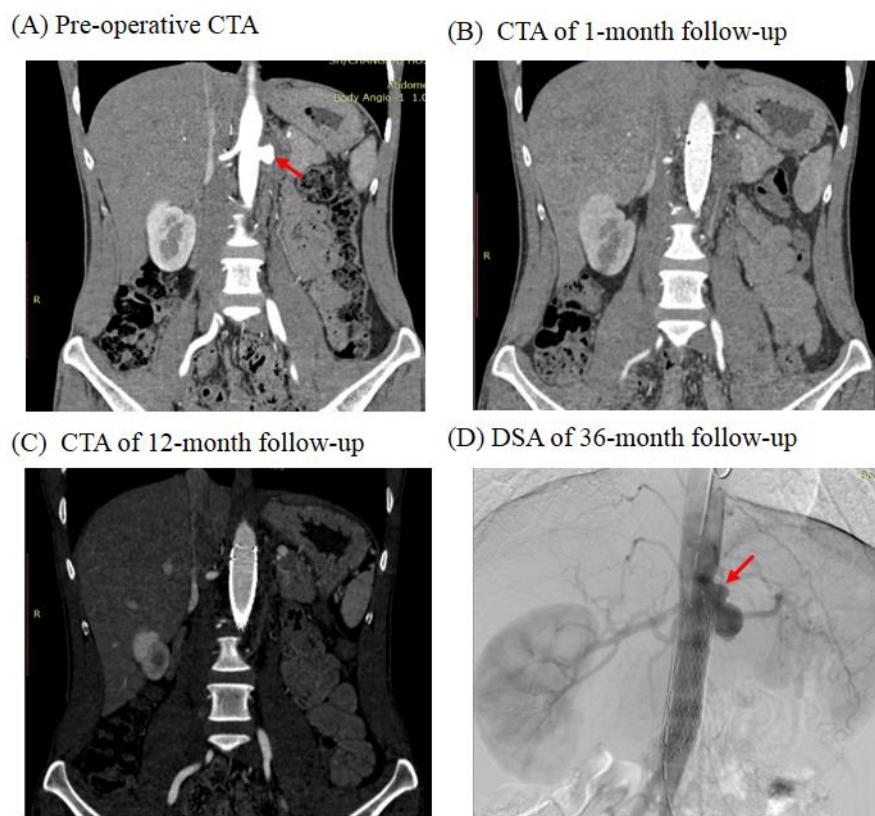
An example of aneurysm recurrence near the landing zone after MOUS treatment. (A) TAA identified on pre-operative CTA; (B) Full occlusion of aneurysm after 1 month; (C) Full occlusion of aneurysm after 12 months; (D) Recurrence of an aneurysm near the proximal landing zone.
